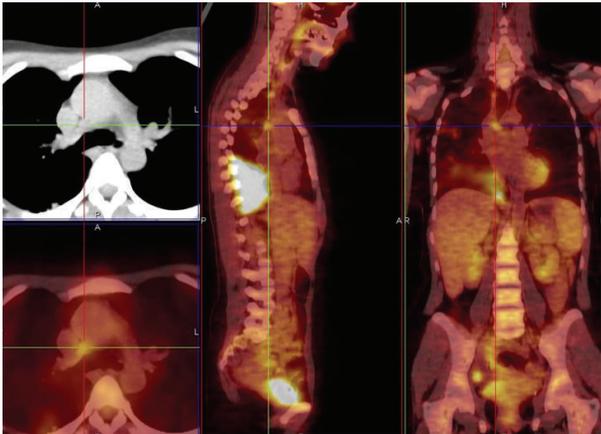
M. tuberculosis* infection with lymph node of Baretz space (4R), SUV max 3.50. Related to patient 11 (PET/CT. Courtesy “V. Monaldi” Hospital).
